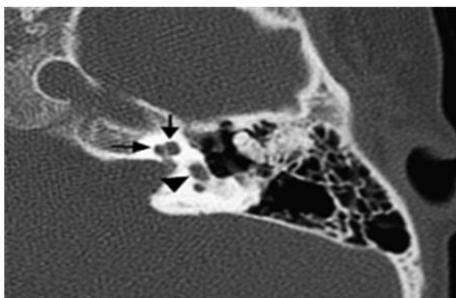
IP type I (number eight "8" malformation). On the axial CT scan the right temporal scan shows the cystic-shaped coclea (arrowhead) and vestibule (arrow) with no internal structures
